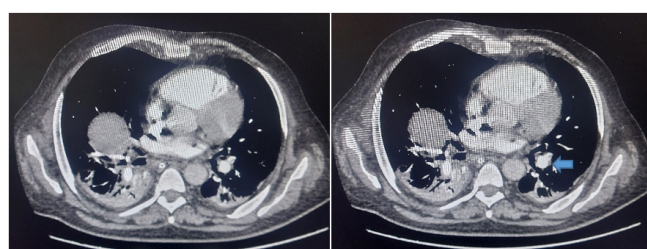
A 61-year-old male patient with COVID-19. The contrast-enhanced CT scan of the chest shows a partial filling defect in the left interlobar artery and segmental branch (arrow), suggesting pulmonary embolism in the left interlobar artery and segmental branch.
